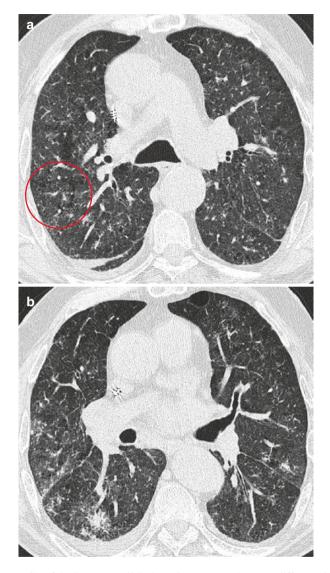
(a) HRCT of the lungs: centrilobular pulmonary emphysema, diffuse reticulations. (b) HRCT of the lungs: centrilobular pulmonary emphysema, GGO and patchy consolidations. (c) HRCT of the lungs: GGO and consolidations, consolidations are with high density (density of the liver parenchyma). (d) CT of the liver (soft tissues window): high diffuse density of the liver parenchyma
